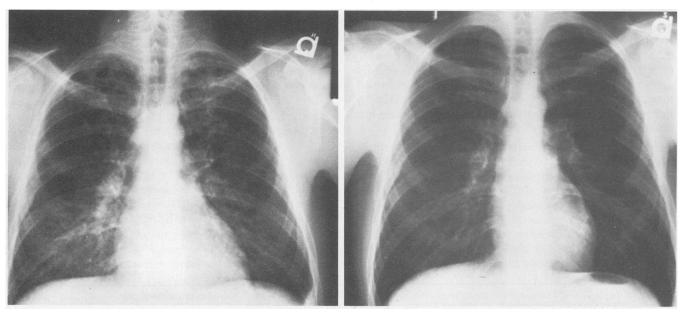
Chest roentgenograms in patient 1, before (left) DFMO therapy showing diffuse infiltrates and after (right) 25 days of DFMO therapy showing resolved infiltrates.
